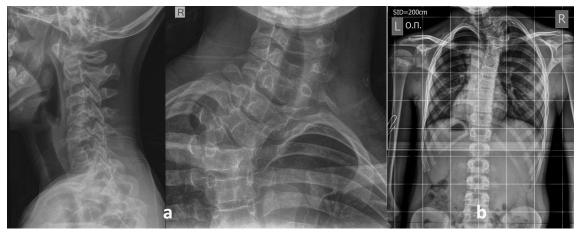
A 15-year-old boy presented with acute torticollis after a sports injury. The lateral radiograph showed loss of the normal lordosis, and the anteroposterior radiograph lateral hemivertebra at the T3 level on the right side, associated with upper thoracic scoliosis (a). His parents reported no previous neck insult or diagnosed disorder. Two weeks later, he had an uneventful recovery while a standing radiograph revealed no additional spinal abnormalities (b). The potential susceptibility of the cervical spine to posttraumatic torticollis in patients with upper thoracic scoliosis remains obscure.
